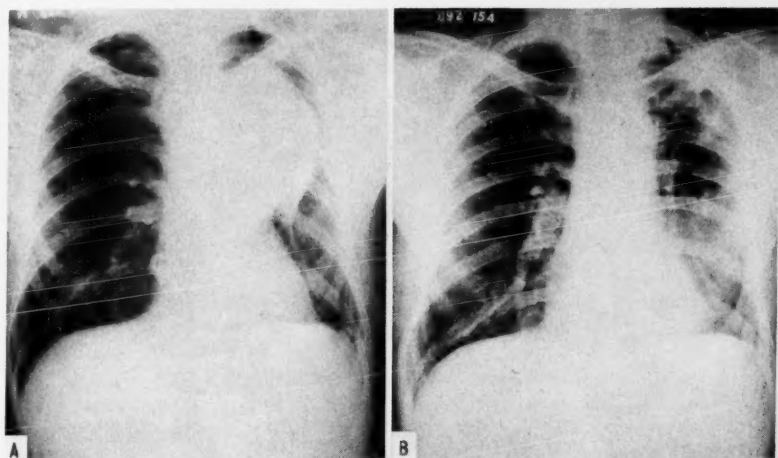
A, Preoperative, and B, postoperative roentgenograms of a 52-year-old man who had severe respiratory obstruction. Bronchoscopically the terminal tracheal region was greatly narrowed and distorted. Selective cineangiographic visualization of the aortic arch in this patient proved the aneurysm to arise distally to the left subclavian artery, and therefore it was eminently suitable for resection. The resection was complicated by distortion of the left pulmonary hilar structures over the aneurysmal wall; the left main pulmonary artery was traumatized, but could be reconstructed.
